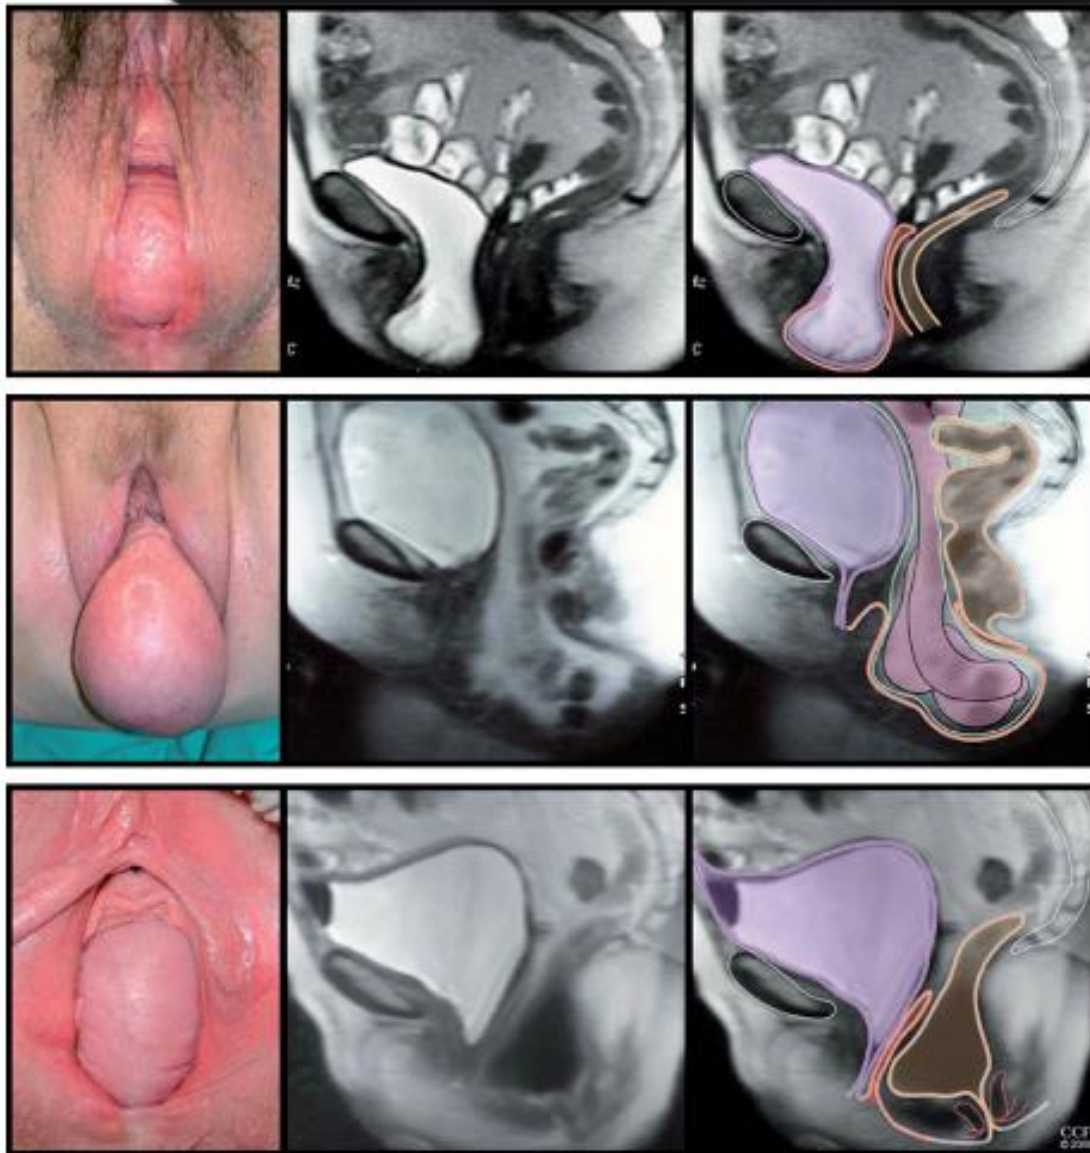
Photographs in the lithotomy position and sagittal magnetic resonance image showing vaginal wall prolapse. Prolapse might include (top to bottom): bladder (cystocele), small bowel (enterocele), or rectum (rectocele). Color codes include purple (bladder), orange (vagina), brown (colon and rectum), and green (peritoneum). Reprinted from *The Lancet*, 369, Jelovsek JE, Maher C, Barber MD, Pelvic organ prolapse, 1027–38, Copyright 2007, with permission from Elsevier. Walters. *Surgical Treatment of Vaginal Apex Prolapse*. *Obstet Gynecol* 2013.
